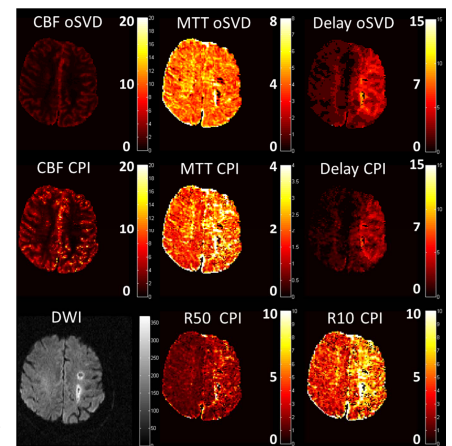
CBF, MTT and Delay estimates for a representative patient using oSVD and CPI methods. The DWI, R50 and R10 map of the same patient (bottom row), where R50 and R10 map clearly showed region of high R50 and R10 values in region of infarct surrounded by an area under ischemic stress in the left hemisphere compared to normal right hemisphere.
